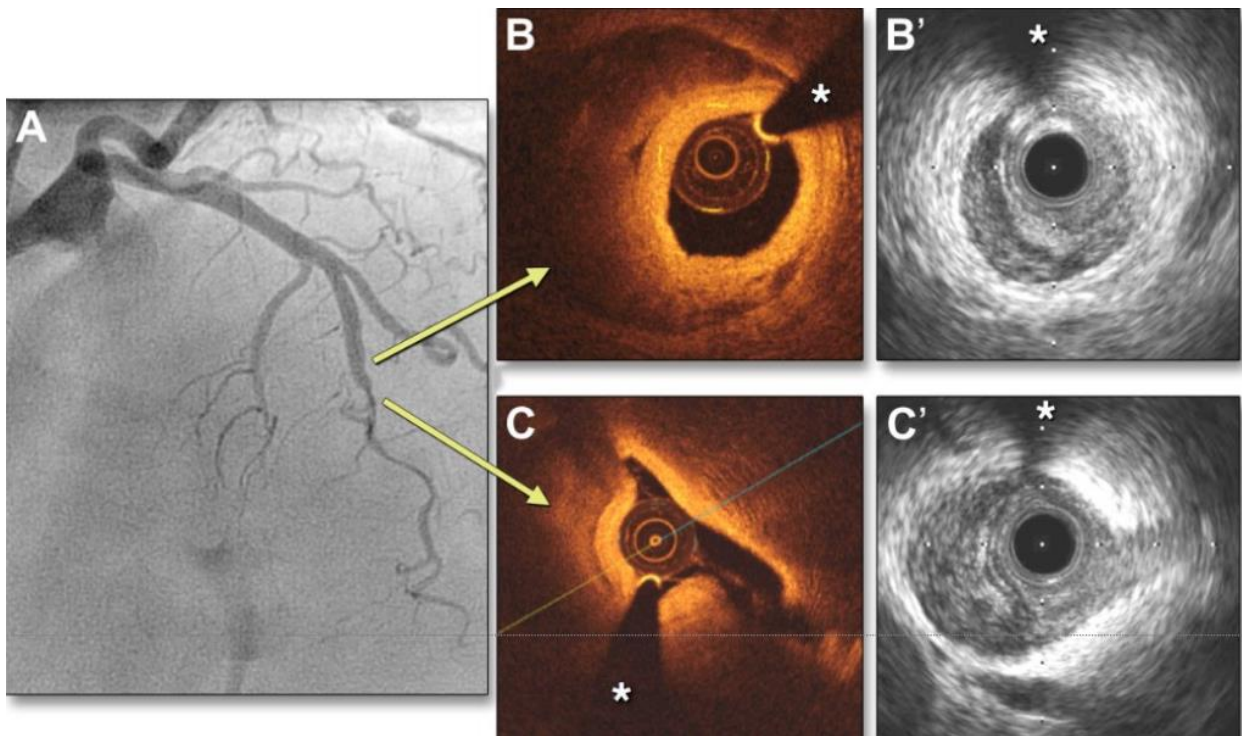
Intravascular ultrasound of LAD.
